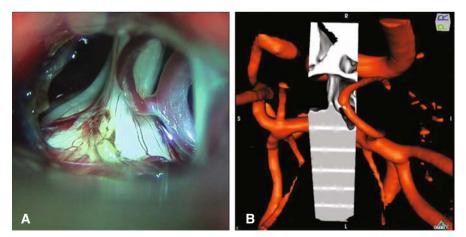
A Intradural exposure of the trigeminal root and compressing vessel at craniotomy. B MR imaging with 3-D reconstruction demonstrating neurovascular compression of the trigeminal nerve by looping the branch of the superior cerebellar artery
